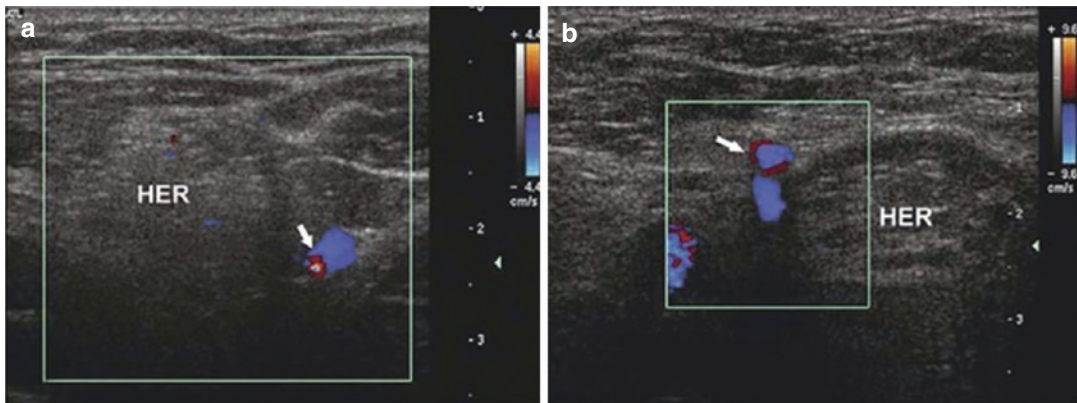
The position of the inferior epigastric artery (arrow), shown in these color Doppler images differentiates an indirect inguinal hernia (a) and direct inguinal hernia (b)
